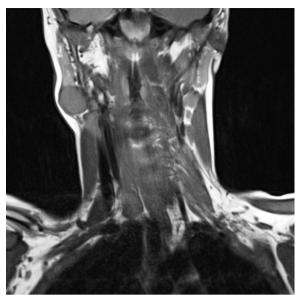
T1-weighted MRI examination showing the tumor located in the right parotid gland with a hypointense pattern.
